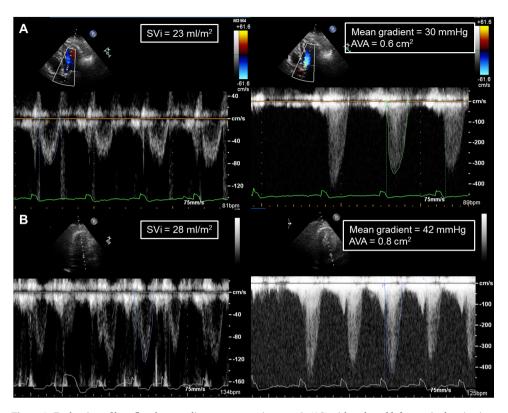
Evaluation of low-flow low-gradient severe aortic stenosis (AS) with reduced left ventricular ejection fraction using low-dose dobutamine stress echocardiography. At baseline, discordant grading of AS severity was apparent: the mean gradient was 30 mmHg and the aortic valve area (AVA) was 0.6 cm^2 . The stroke volume index (SVi) was 23 ml/m^2 , corresponding with low-flow low-gradient AS (*panel A*). Low-dose dobutamine stress echocardiography was performed to differentiate between true severe AS and pseudosevere AS. This resulted in an increase of the mean gradient to 42 mmHg and of the SVi by 22% to 28 ml/m^2 while the AVA remained <1.0 cm², consistent with classical low-flow low-gradient true severe AS and the presence of flow reserve (i.e., increase of SVi > 20%)(*panel B*).
